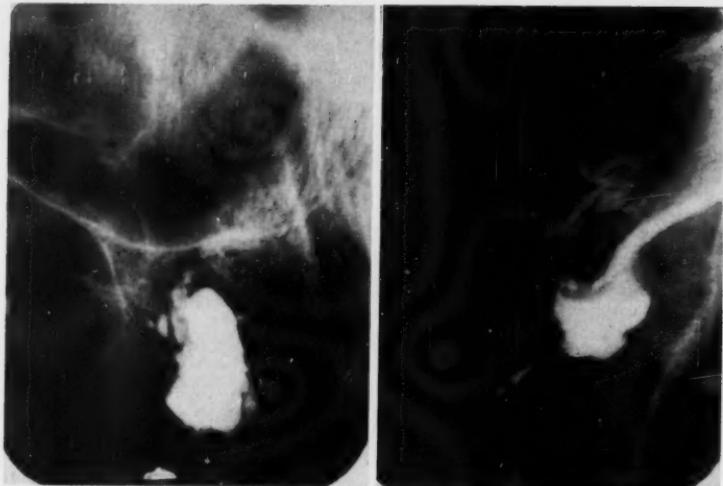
Dental radiographs showing the alveolar foreign bodies in the left cuspid and molar areas.
